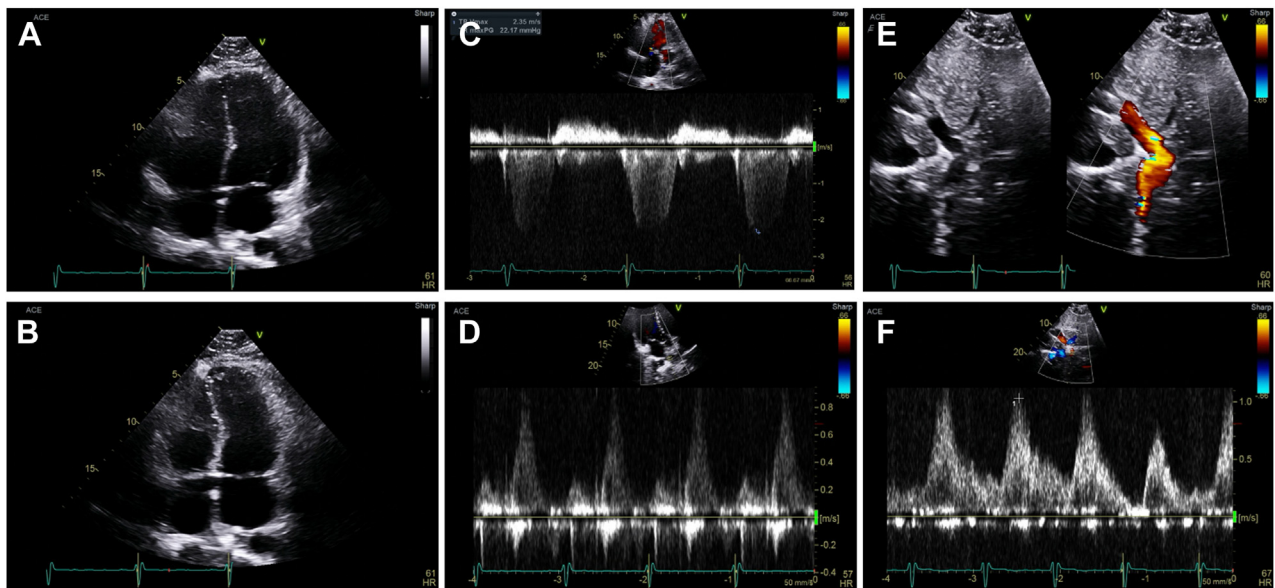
TTE images from the patient's first study demonstrate normal left ventricular size and function and mild RV enlargement (RV length 8.3 cm, RV basal diameter 6.4 cm, RV midcavitary diameter 5.3 cm) and normal systolic function (RVEF 49%). Apical four-chamber view in diastole (A) and systole (B). Right upper PV Doppler captured in apical three-chamber (C) and four-chamber views (D). Subcostal view demonstrates the VV draining directly into the hepatic vein, with a minimal gradient of 4 mm Hg (E, F).
